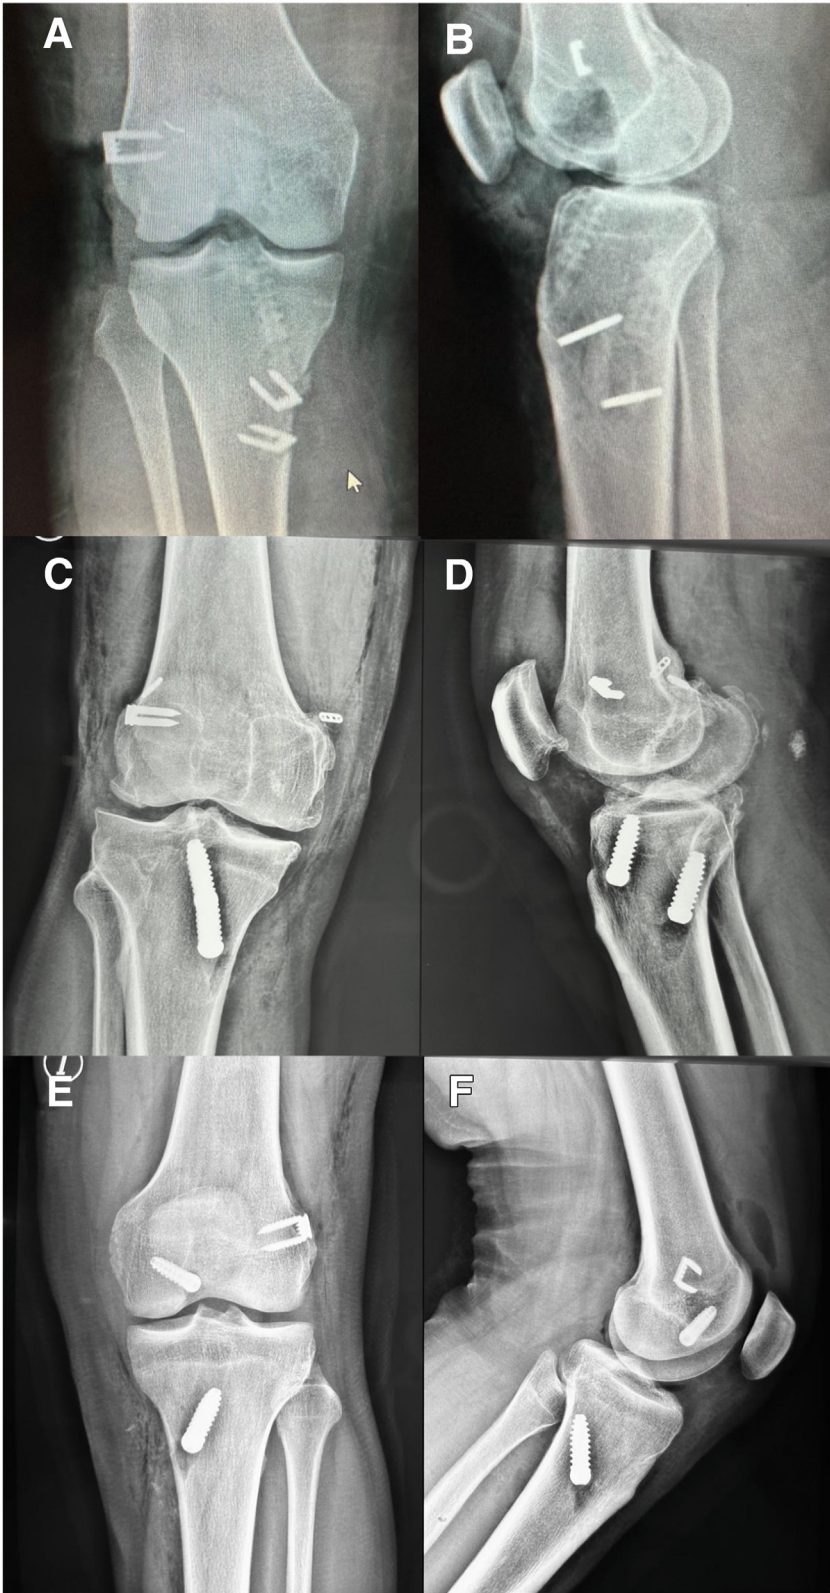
Immediate postoperative radiographs of 2 cases (right knees) with anterior cruciate ligament and posterior cruciate ligament reconstructions with the addition of a posterolateral tenodesis (A-D) and a case of an isolated complete posterior cruciate ligament injury (left knee) (E-F). In all cases, the tenodesis was fixed with staples.
